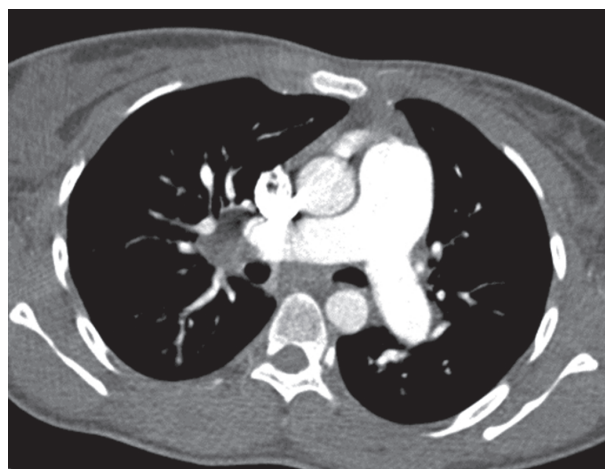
An axial contrasted computed tomography scan of the chest showing enlarged main pulmonary trunk suggesting pulmonary hypertension and extensive mediastinal lymphadenopathy.
